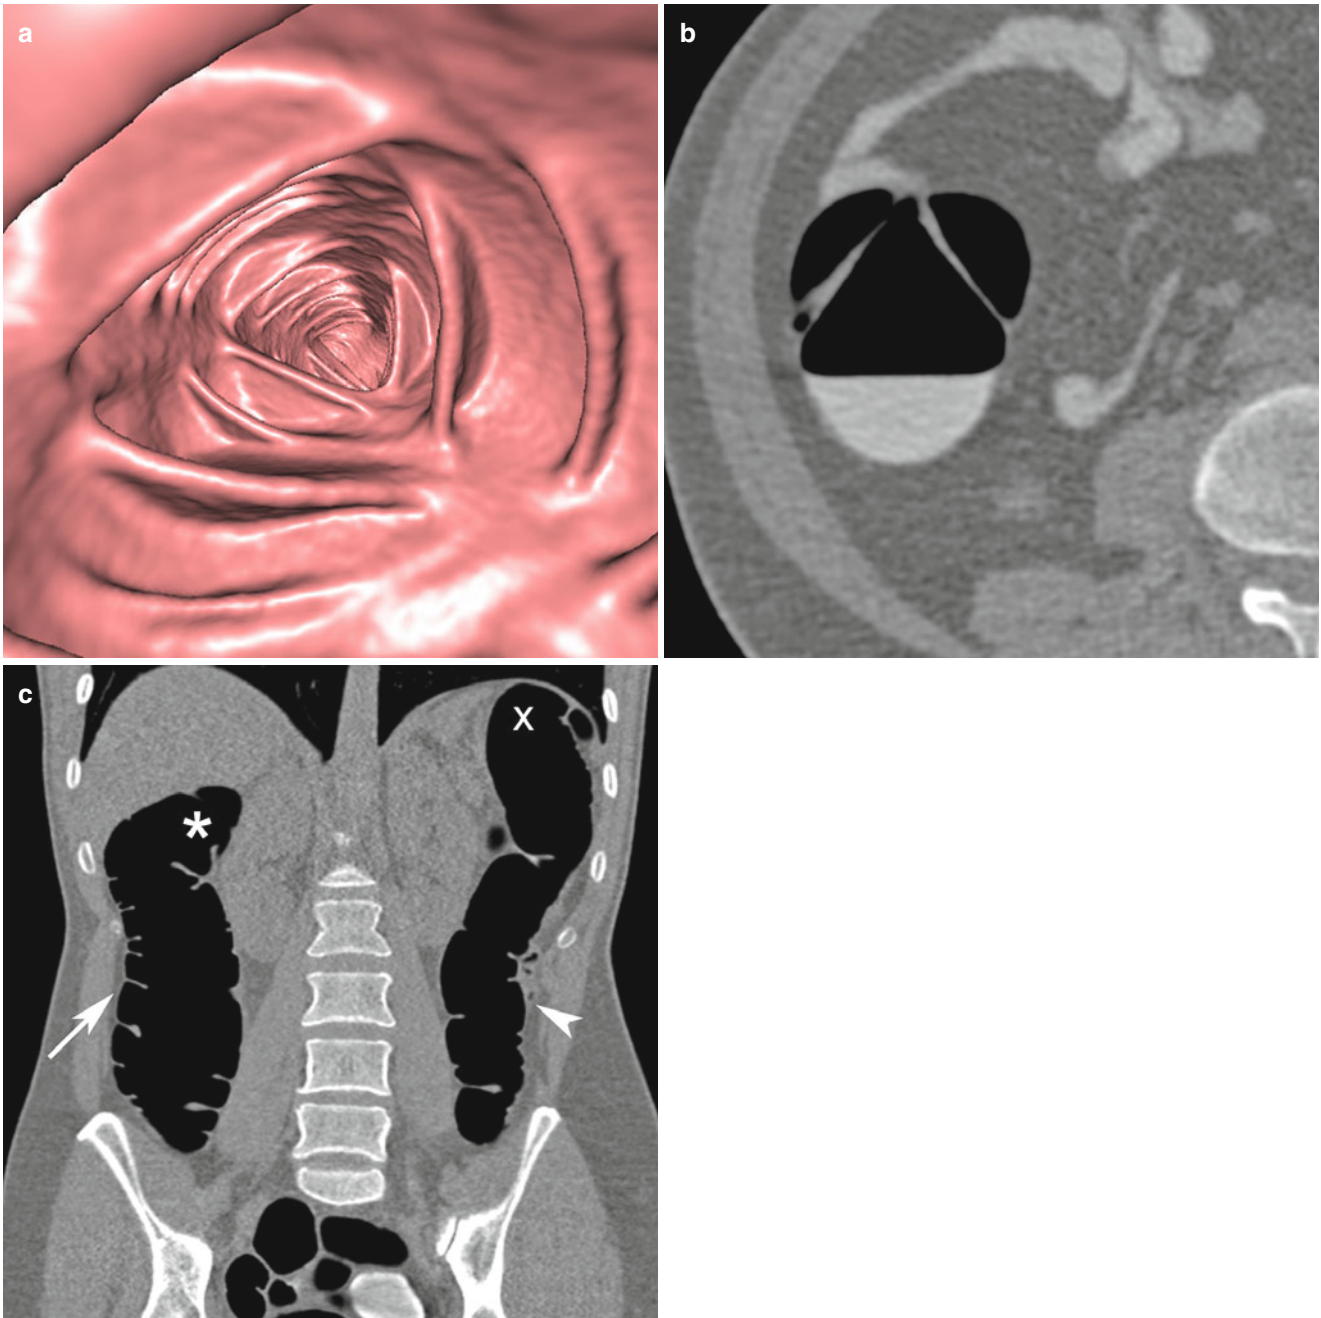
(a) Antegrade endoluminal 3D CT view and (b) axial 2D CT image of the ascending colon, showing a triangular cross section and distinct haustration. (c) Coronal 2D CT image showing the ascending colon (*arrow*) extending retroperitoneally into the right abdomen. Note the right (*) and left (X) flexure and the descending colon (*arrowhead*)
